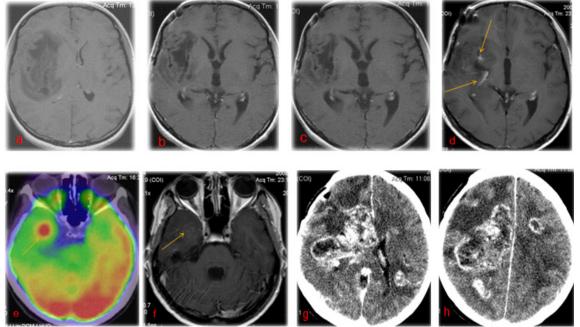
A. Axial T1- weighted contrast enhanced MRI image show FTP area of hiposignal without contrast enhancement, B. and C. Images obtained 9 and 21 months later at the same patient after surgery and 6 cure of LINAC stable images, D. axial MRI images at 22 months are sowing 2 areas of contrast enhancement which weren't present on the previous exam, E. PET scan is showing an area of hipermetabolism in the right temporal lobe and F. the correspondent images on T1-weighted with contrast enhanced MRI image G. and H. at 23 months after second surgery CT images obtained 1 month later show involvement of both cerebral hemispheres
